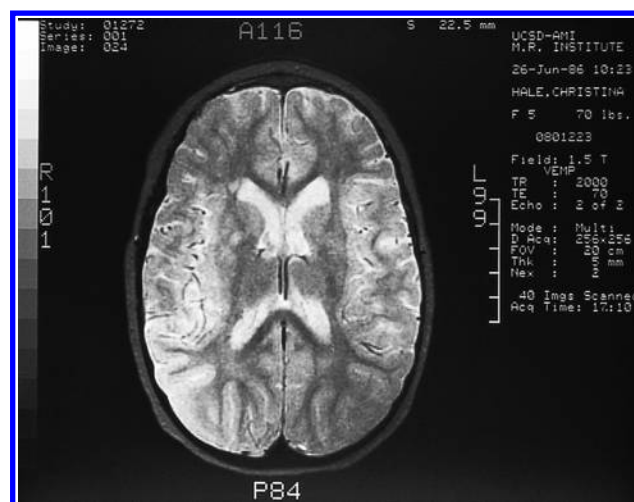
Magnetic resonance image of CH, a patient with methylmalonyl CoA mutase deficiency. There was a diffuse pattern of abnormal signal intensity in the cerebral hemispheres and focal areas of abnormal signal in the basal ganglia.
